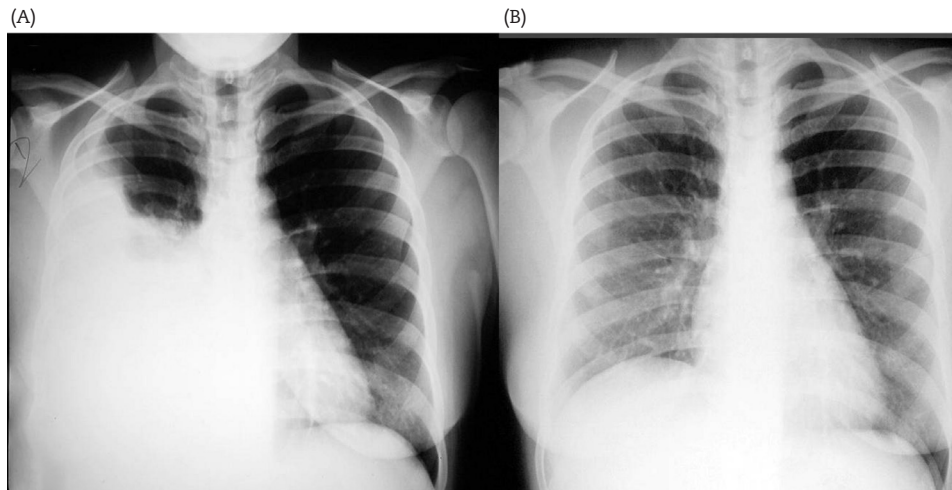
Chest X-ray at admission (A) and 2 weeks after hospital discharge (B).
